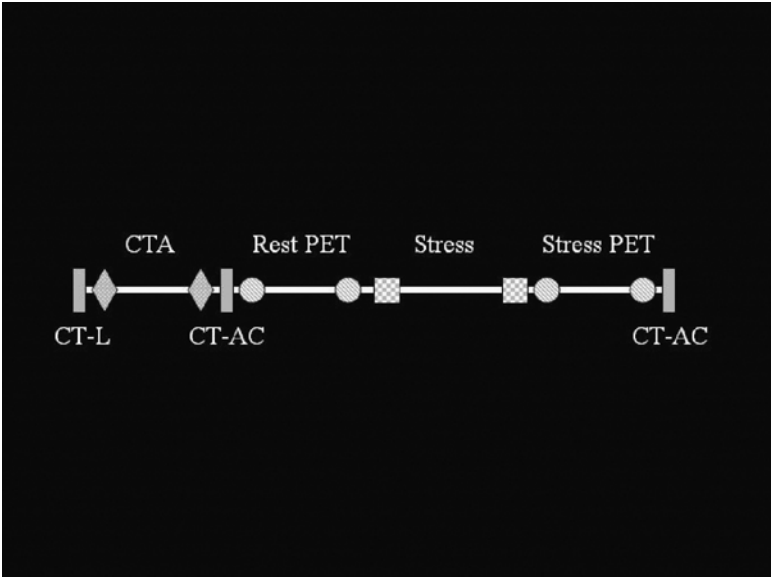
Methodology for acquisition of PET/CT scan. CT-L = localizing CT scan; CT-AC = attenuation correction CT scan; CTA = CT angiogram.
